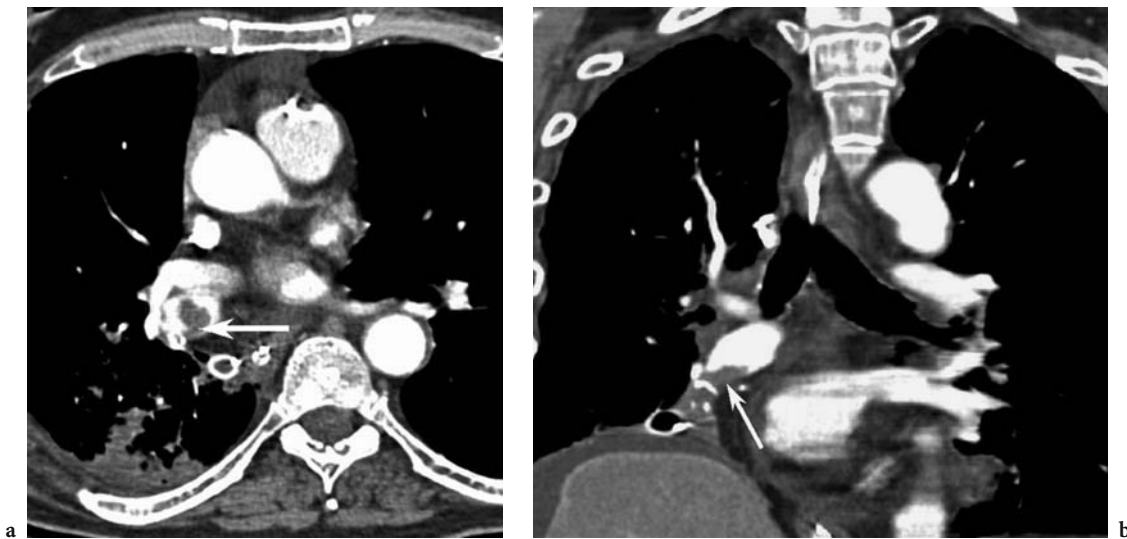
Contrast-enhanced multidetector-row CT scan in a 54-year-old man 5 days after right middle and lower lobectomies. Axial sections (a) and coronal multiplanar reformats (b) show filling defects in the stump of the right pulmonary artery, representing thrombus formation arising from the suture line as opposed to PE
